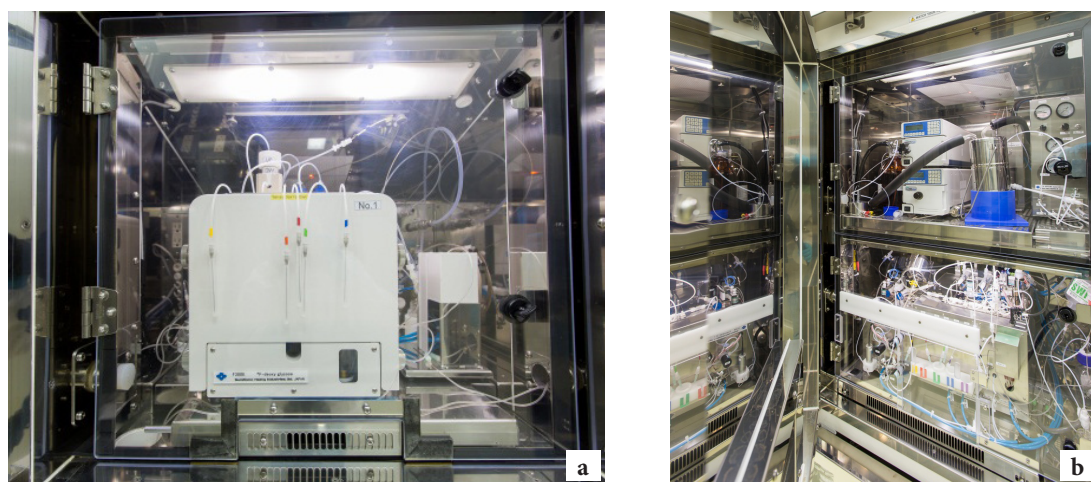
The F300E synthesizer for ^{18}F -FDG production (a): and the CFN multi-purpose synthesizer MPS-100 for production of other radiopharmaceuticals (b); inside the double-type and the unit-type class A hot cells in the ISO14644-1:1999(E) certified radiopharmaceutical cleanroom
